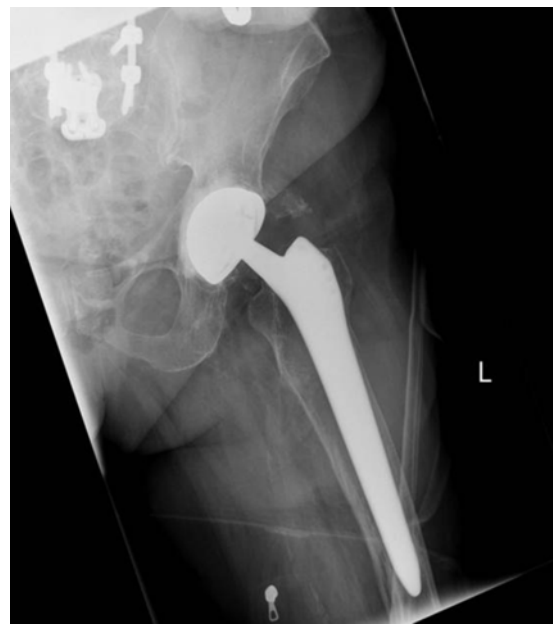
Axial X-ray imaging of Figure 3.
